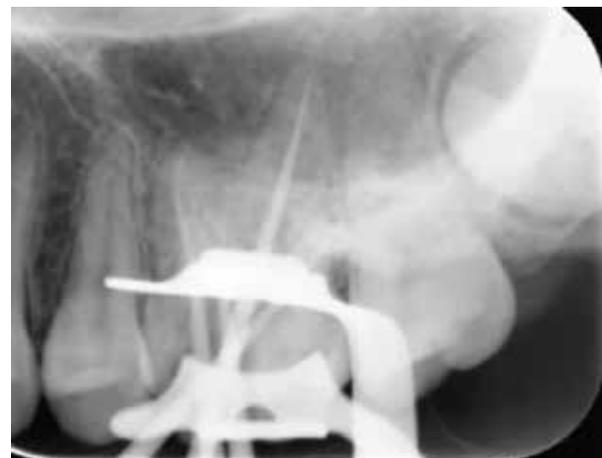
Radiographic image showing master cone selection.
